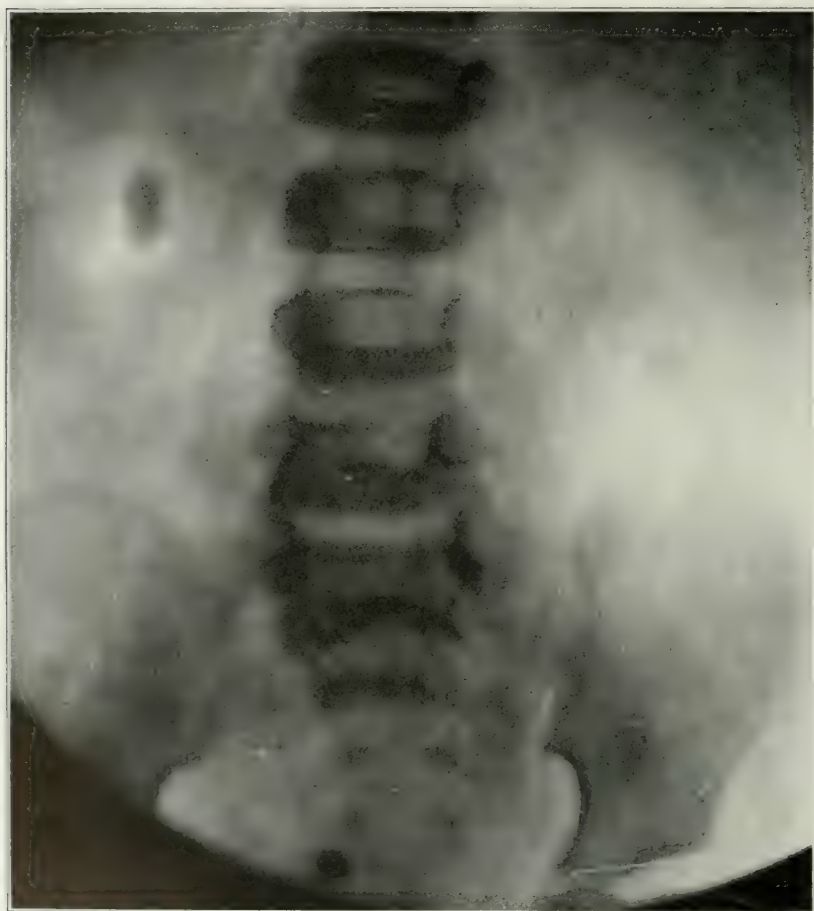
Radiograph, taken nine months after that shown in Fig. 2, showing two calculi in right kidney and destruction of kidney substance. Also the bladder stone as in Fig. 2. In addition, two shadows are shown in the left kidney region.
